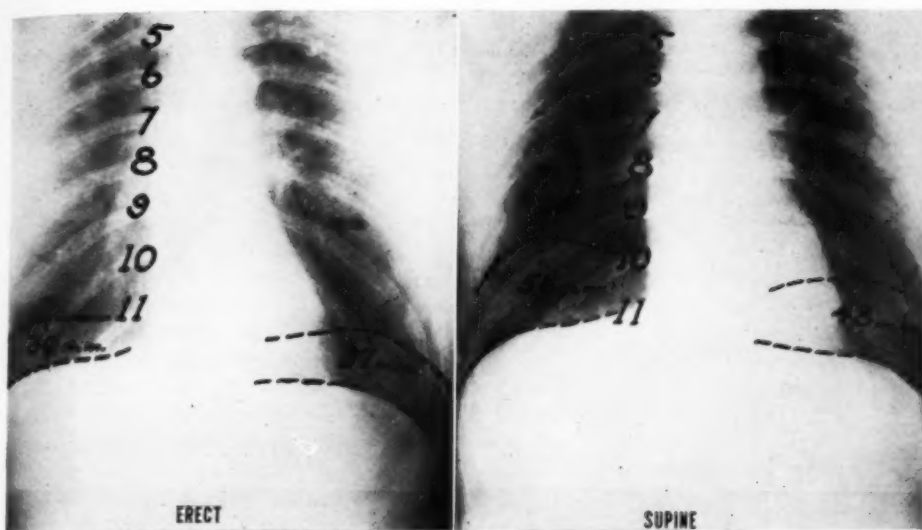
Roentgen exposure (left) made in the erect posture without a belt, showing the low position of the diaphragm in expiration and the reduced excursion with inspiration, and roentgen exposure (right) showing the position and movement of the diaphragm in the same patient in the supine position. The latter relationships are found in the erect posture also if an elastic supporting abdominal belt is worn. The position of the diaphragm on the original films has been marked for identification. A double exposure was made in inspiration and expiration.
